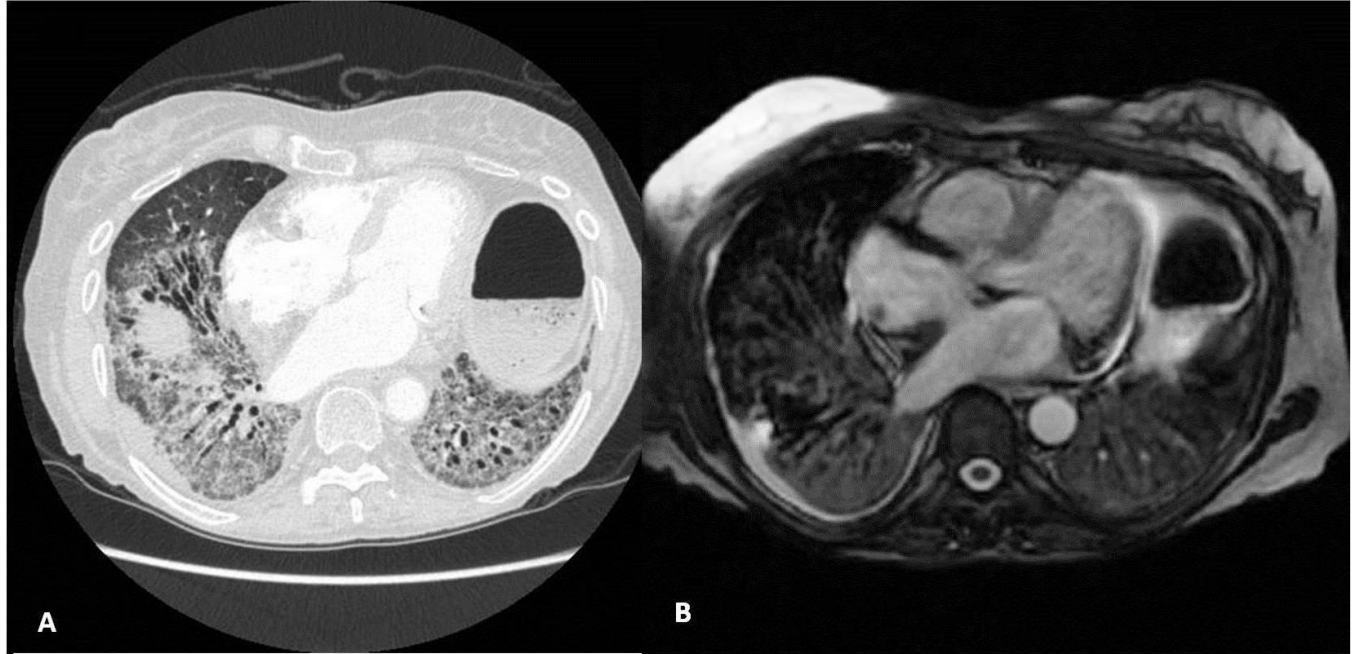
Typical NSIP pattern of fibrosis with presence traction bronchiectasis appreciated on both CT (A) and bSSFP MRI (B)
